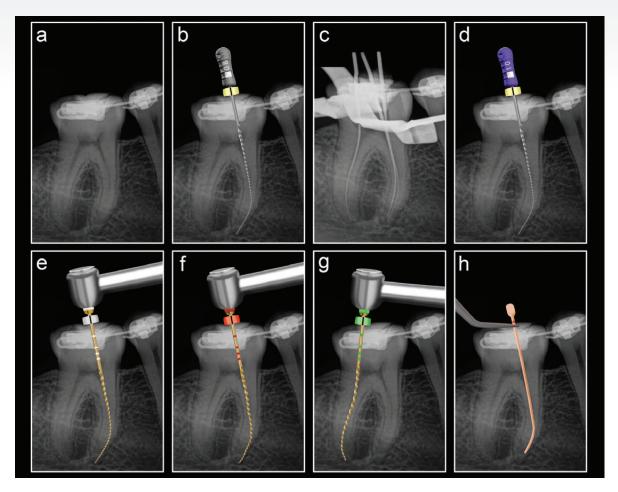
(a) Pre-operative peri-apical radiograph of mandibular first molar; (b) Canals were located and negotiated to patency with a size 08 K-File; (c) Working length was determined with an electronic apex locator and confirmed radiographically; (d) Reproducible micro glide paths were prepared with a 10 K-File; (e) Glide paths were expanded using the TruNatomy Glider; (f) Mesial root canals systems were prepared with a TruNatomy Prime instrument; (g) Distal root canal system was prepared with a TruNatomy Medium instrument; (h) 17% EDTA was activated using the manual dynamic agitation technique with a gutta percha point
